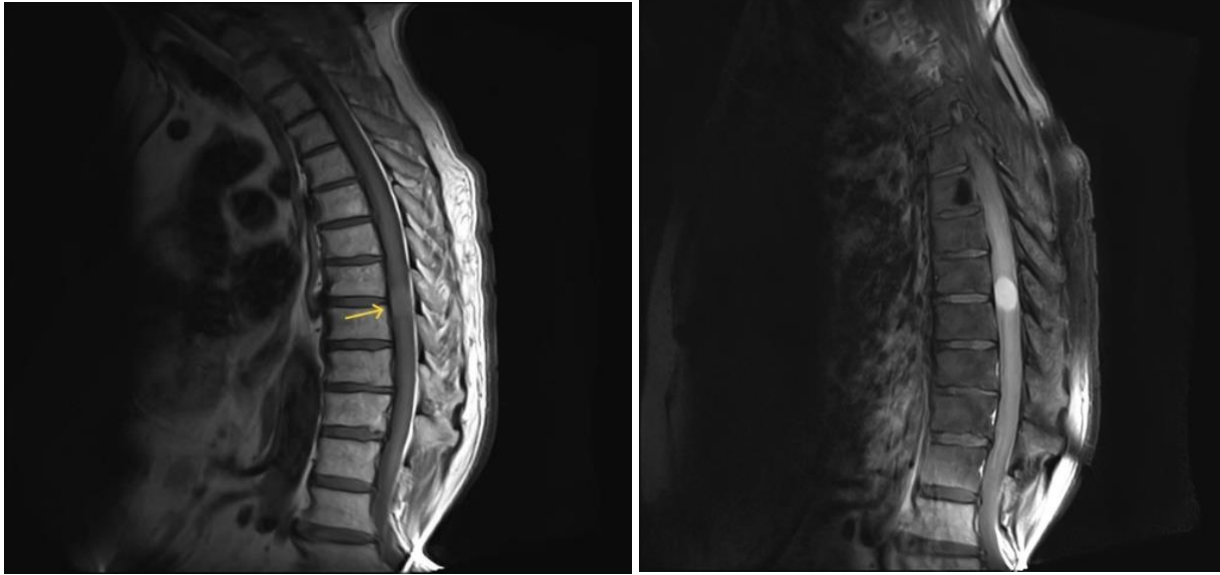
Sagittal T1 weighted MRI sequences with and without gadolinium: Intradural hyperintense lesion at T8-T9 level, and contrast enhancement after gadolinium administration.
